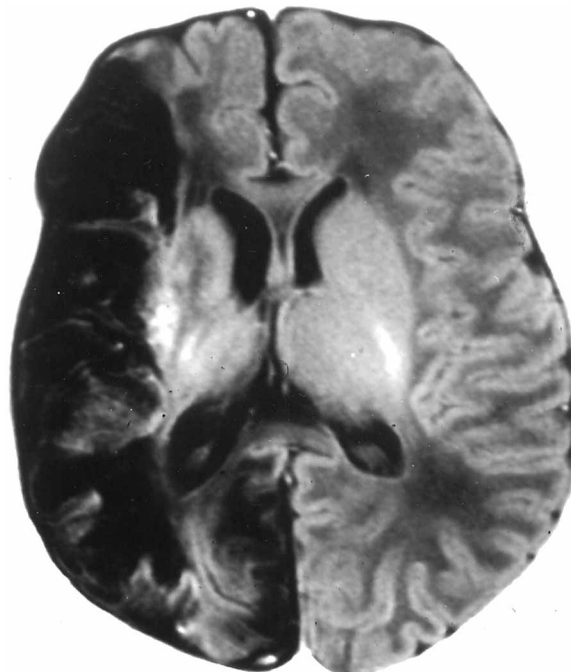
MRI patient 3: large hypointense in the right hemisphere, respecting the frontal and the internal part of the basal ganglia (axial T1 sequence).
